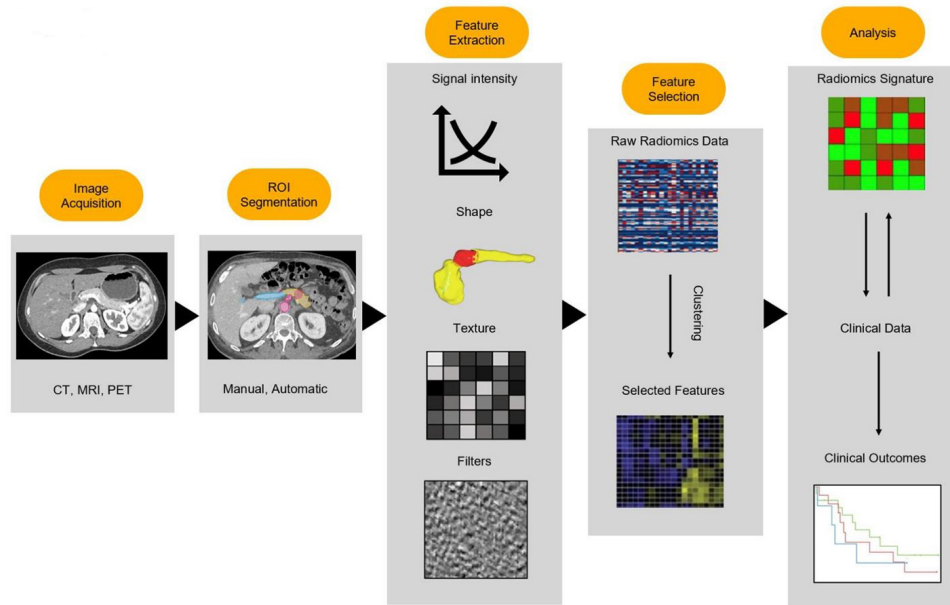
Current approach to radiomic analysis. CT: Computed tomography; MRI: magnetic resonance imaging; ROI: region of interest.
